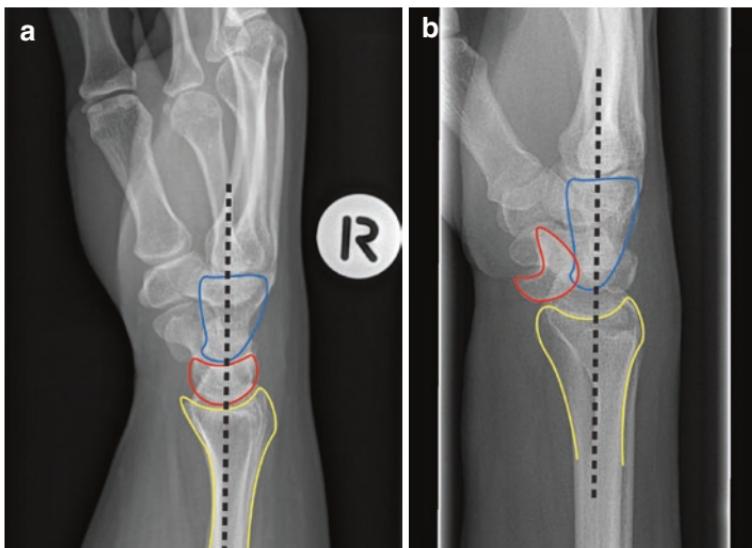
Lateral wrist X-ray: (a) normal alignment (yellow, radius; red, lunate; blue, capitate), (b) lunate dislocation – note the “spilled teacup” sign of the lunate. (Reprinted from <http://www.emcurious.com/blog-1/2015/7/8/1ftadghymctqd2flw27ao4zw1m6tb> with permission from Creative Commons License: <https://creativecommons.org/licenses/by/4.0/>)
